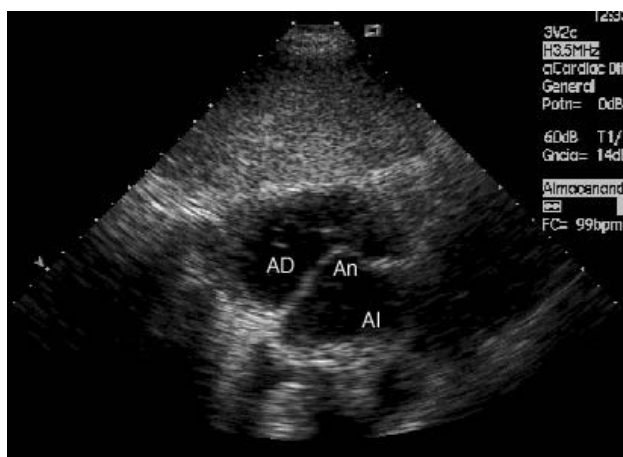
Subcostal echocardiography shows the presence of an atrial septal aneurysm protruding into the right atrium (RA). LA indicates left atrium.
